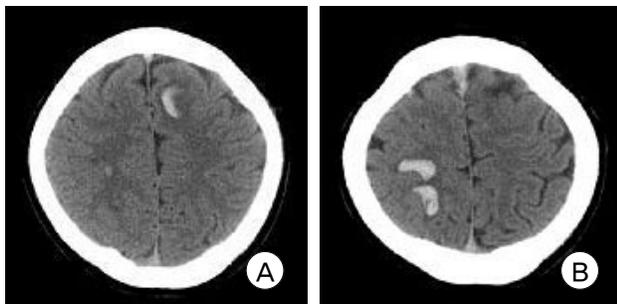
On initial brain computerized tomography (CT) scans, there are multiple hemorrhages in the subcortical area of both middle frontal gyrus (A, B).
